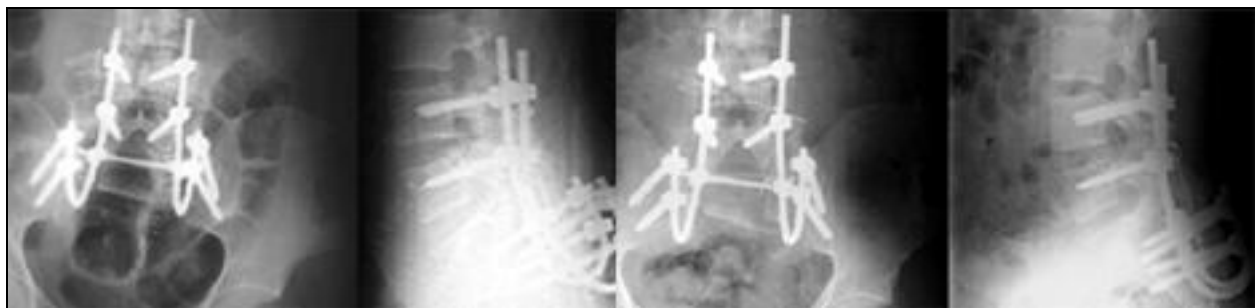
(A,B): (A) Per-operative AP and lateral X-rays showing iliolumbar instrumentation and bone grafting. (B) Follow-up X-rays performed nine months after surgery showing satisfactory fusion
